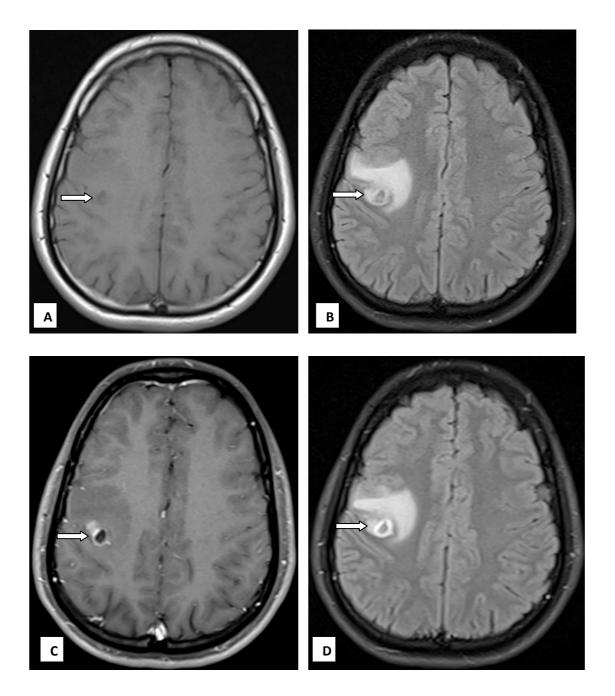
MRI Brain axial sections of 21-year-old male diagnosed with neurocysticercosis shows hypointense lesion on (A) T1WI. On (B) T2 FLAIR image a hypointense lesion with hyperintense rim and perilesional edema is noted. The lesion demonstrates moderate ring enhancement on (C) T1 FS PC and avid enhancement on (D) T2 FLAIR PC image. The extent of perilesional edema is better appreciated on T2 FLAIR PC image than T1 FS PC image.
